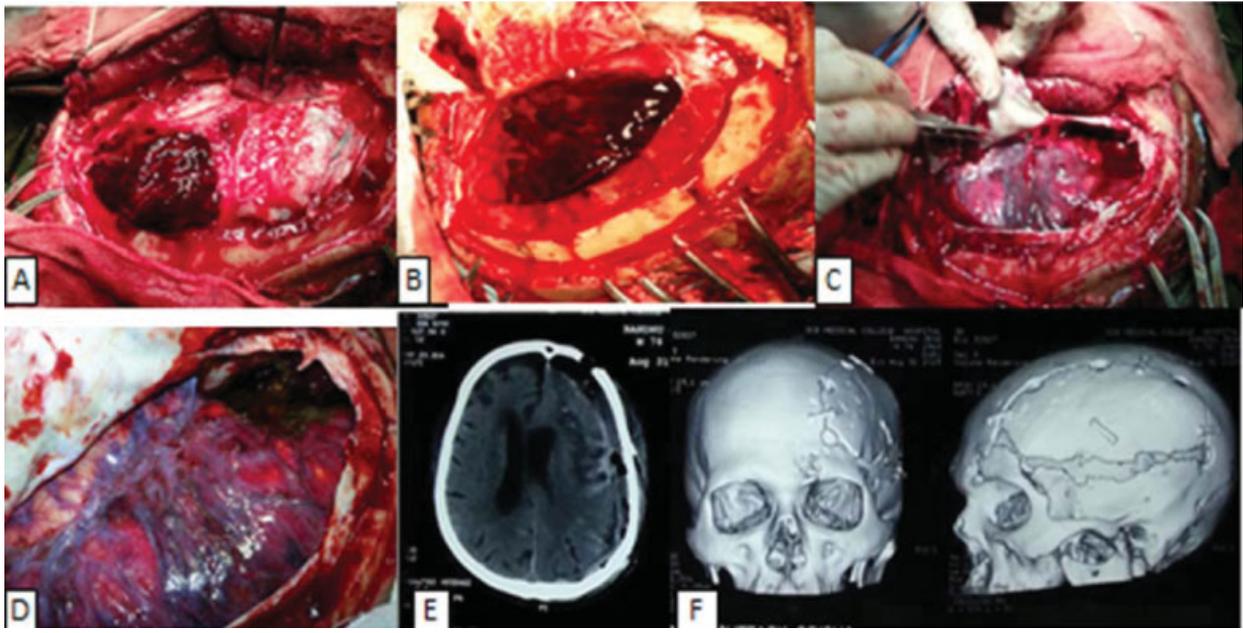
(A) Intraoperative image showing EDH, (B) ASDH, (C) frontal contusion, (D) SAH, (E) postoperative NCCT axial view showing no mass lesion with minimal MLS and (F) postoperative 3D reconstruction of a skull showing craniotomy defect. 3D, three-dimensional; ASDH, acute subdural hematoma; EDH, epidural hematoma; MLS, midline shift; NCCT, noncontrast computed tomography; SAH, subarachnoid hemorrhage.
